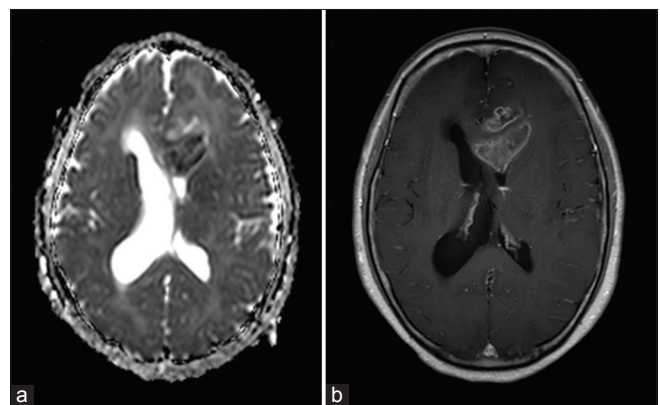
Magnetic resonance images of GBM patients. (a) The axial position image of ADC showed that the parenchyma of the left frontal lesion was markedly enhanced. (b) At the corresponding level of ADC image, the enhanced part of the lesion showed low signal in the ADC image
